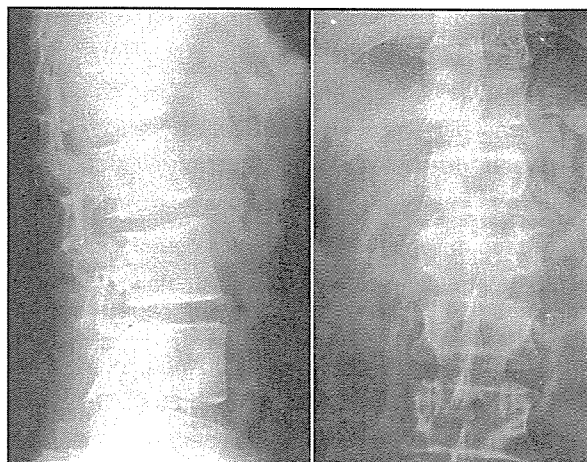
Preoperative AP and lateral x-ray of 18 years old woman with L1 burst fracture.
